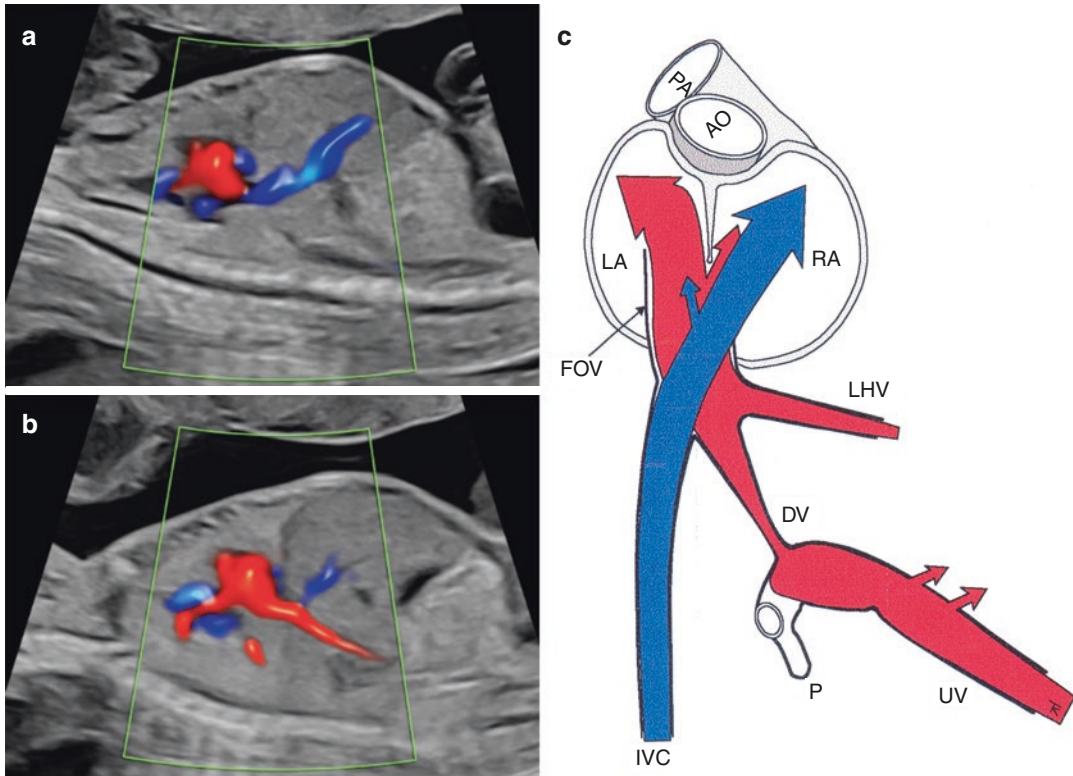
Panel (a): Color Doppler imaging at 19 weeks of gestation showing the umbilical flow entering the ductus venosus (DV) streaming in a steep dorsal direction to cross the inferior vena cava (IVC) and hit the left atrium (LA) directly. Apart from the upper-most left compartment, the IVC is not visualized in this plane. Note that the LA is the most posterior atrium since the heart is rotated toward the left. Panel (b): In a parallel plane, a fraction to the right of the previous insonation, the entire IVC is observed directing abdominal blood in a steep slightly anterior direction to enter the right atrium (RA). Panel (c): Graphical presentation of the two pathways operating in two neighboring planes and crossing in the distended upper section of the IVC, the oxygenated umbilical blood
